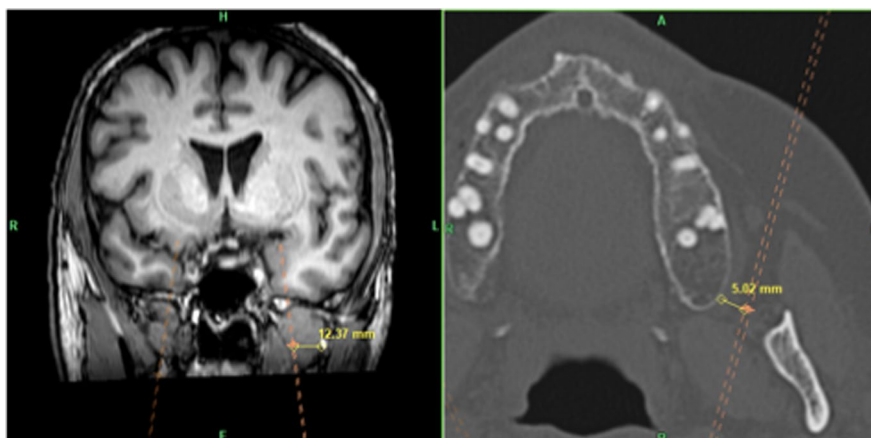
MRI displays the distance of trajectory to the A. maxilaris, CT displays the distance to the maxilla
